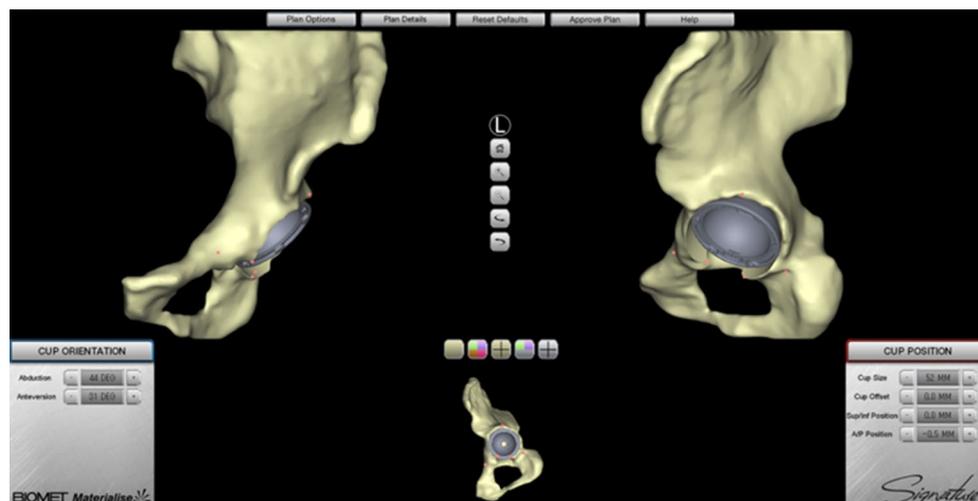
Preoperative planning for the acetabular component in MRI planning software. The planned implant inclination and anteversion angle were described in accordance with the CT-based surgical preoperative planning
